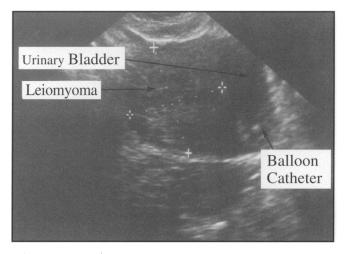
Ultrasound scan – Transverse scanning shows a mass of mixed echogenicity. It was unclear whether this was extrinsic or intrinsic. A catheter balloon can be seen lying on the left side of the bladder.
